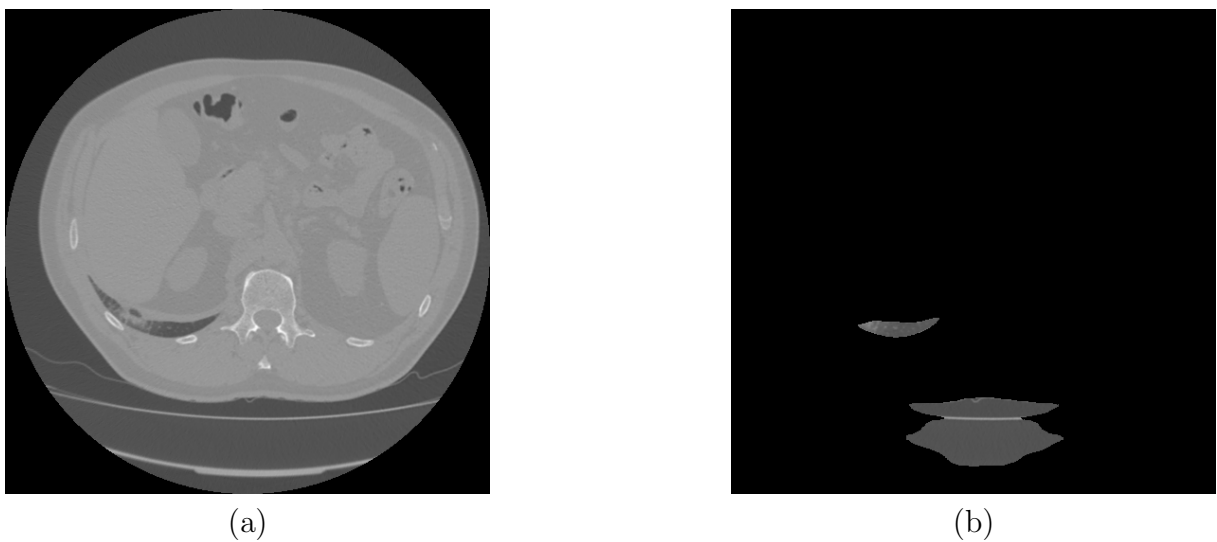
Example of image used only on Non-segmented classification framework. (a) Original CT image. (b) Segmented image where the lung parenchyma isn't preserved.
